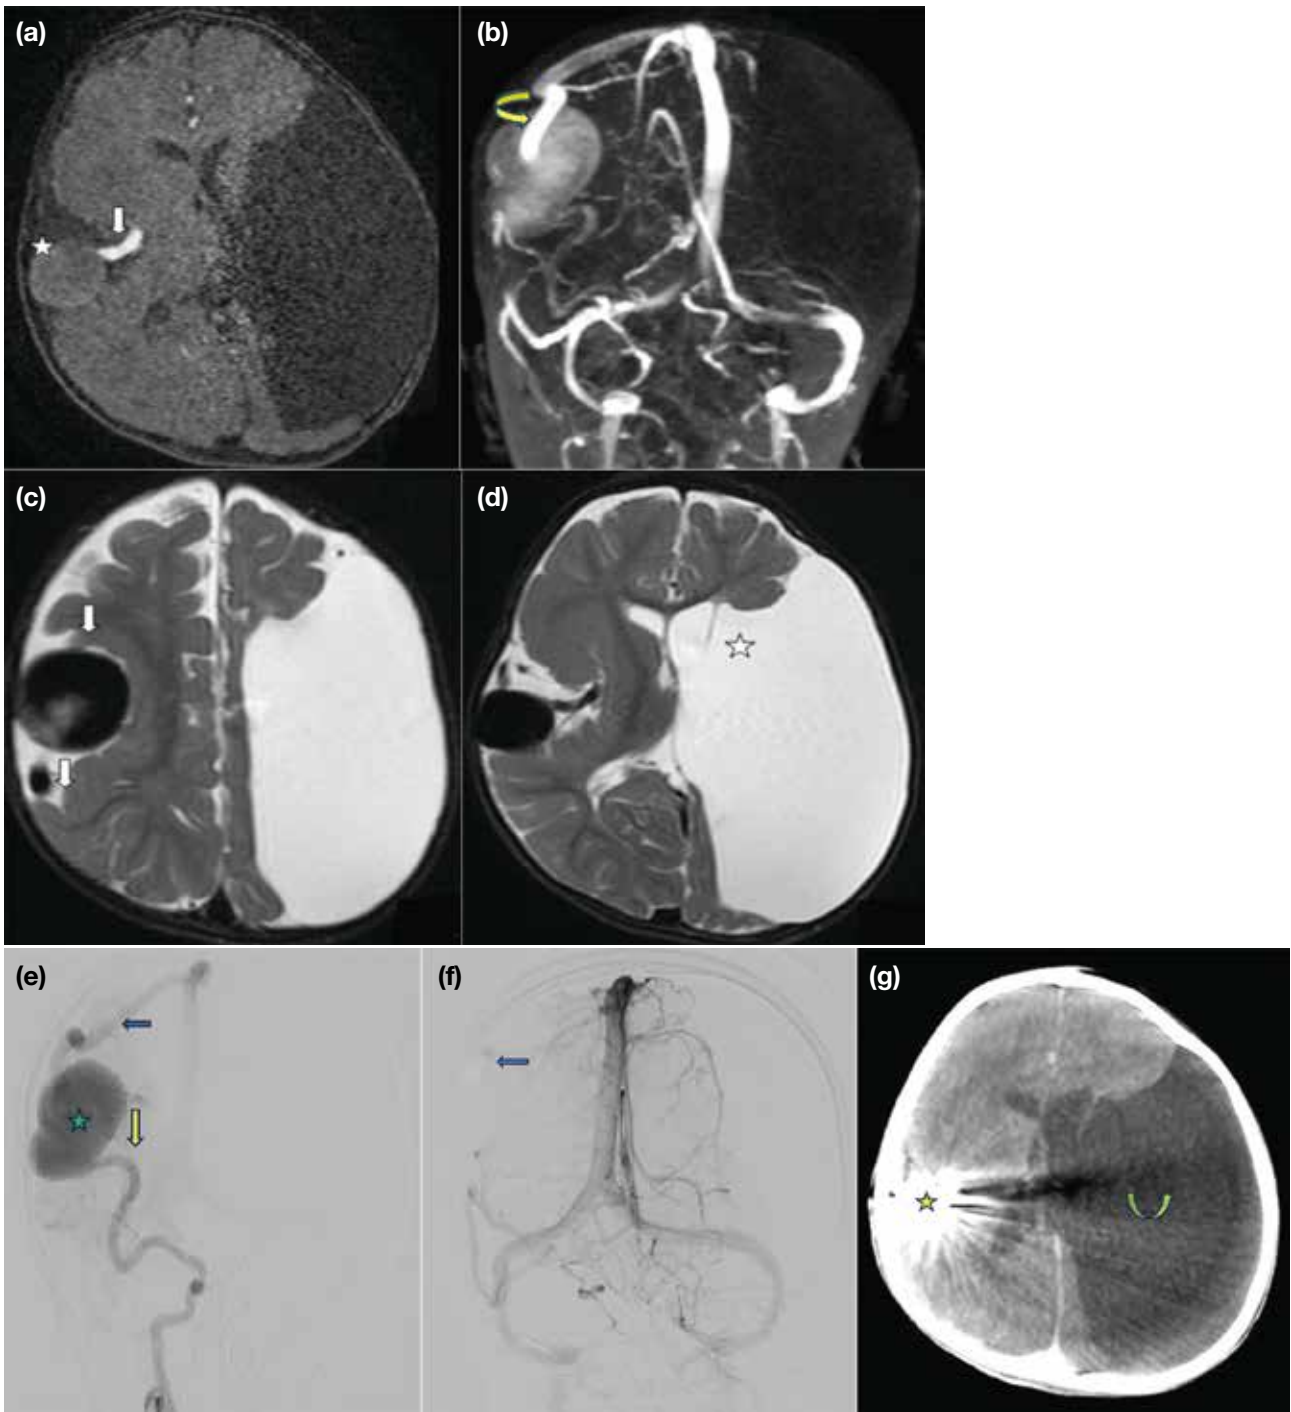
Case 2. (a) Axial magnetic resonance angiography showing a well-defined extra-axial lesion (star) in the right transverse temporal sulcus communicating with a prominent feeder from the M4 segment of the right middle cerebral artery (white arrow). There is associated left cerebral hemisphere atrophy. (b) Reformatted magnetic resonance venography showing a bilobed extra-axial lesion with a prominent vein representing the superior anastomotic vein of Trolard (curved yellow arrow) seen draining the lesion into the superior sagittal sinus. (c) Axial T2-weighted image (T2WI) showing a pachygyria-polymicrogyria complex (white arrows) involving the right parietal lobe adjacent to the abovementioned lesion. The lesion appears hypointense on T2WI, likely due to flow voids, suggestive of a high-flow arteriovenous fistula. (d) Axial T2WI shows an associated porencephalic cyst (star) involving the left cerebral hemisphere communicating with the frontal horn of the left lateral ventricle. (e) Preprocedural digital subtraction angiography image showing pial arteriovenous fistula involving the right fronto-parietal region fed by a right middle cerebral artery–M4 branch (yellow arrow) and draining via the vein of Trolard (blue arrow) into the superior sagittal sinus with a large venous sac (star). (f) The arteriovenous malformation (AVM) was embolised and post-procedure angiography image shows complete exclusion of the AVM from the circulation (blue arrow). (g) A non-contrast axial computed tomography of the brain shows streak artifacts secondary to post-embolisation status of the AVM (yellow star). Associated left cerebral hemisphere atrophy is noted (curved green arrow).
